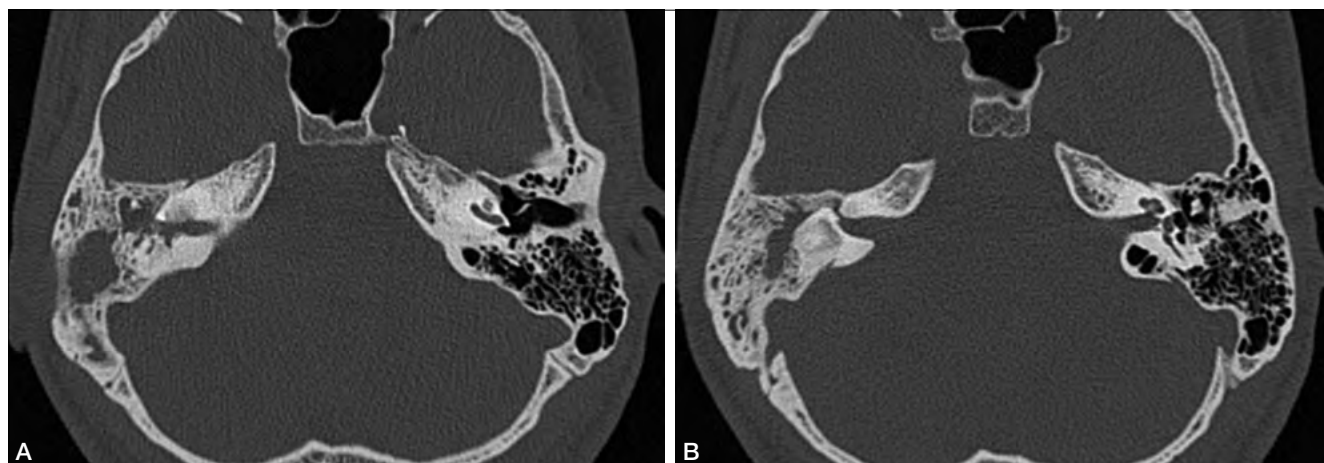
CT scan with bone window after the first mastoidectomy; A) axial view: regular outcomes of the standard mastoidectomy; complete ossification of the cochlea; B) complete ossification of the vestibule and lateral semicircular canal.
